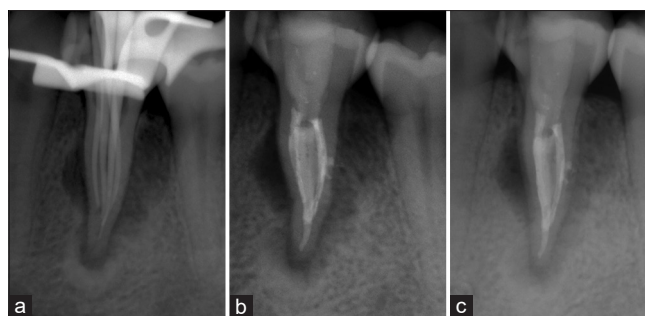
(a) Master cone periapical radiograph. (b) Final periapical radiograph. (c) Periapical radiograph at 6 months reveal visit
